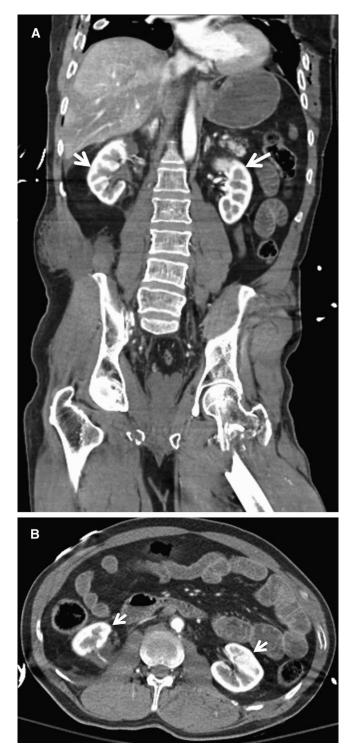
Coronal (A) and axial (B) slice contrast-enhanced abdominal computed tomography, showing increased renal parenchymal enhancement bilaterally (arrows), evidence of increased small bowel mucosal enhancement, and hyperenhancing adrenals consistent with hypovolemic shock complex.
